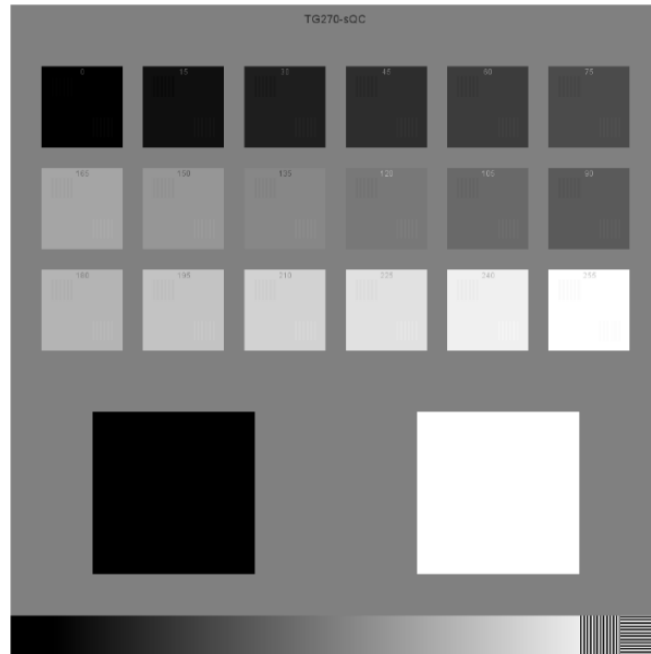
TG270-sQC test pattern for quality control of x-ray workstation displays and printed images. From reference 2.
